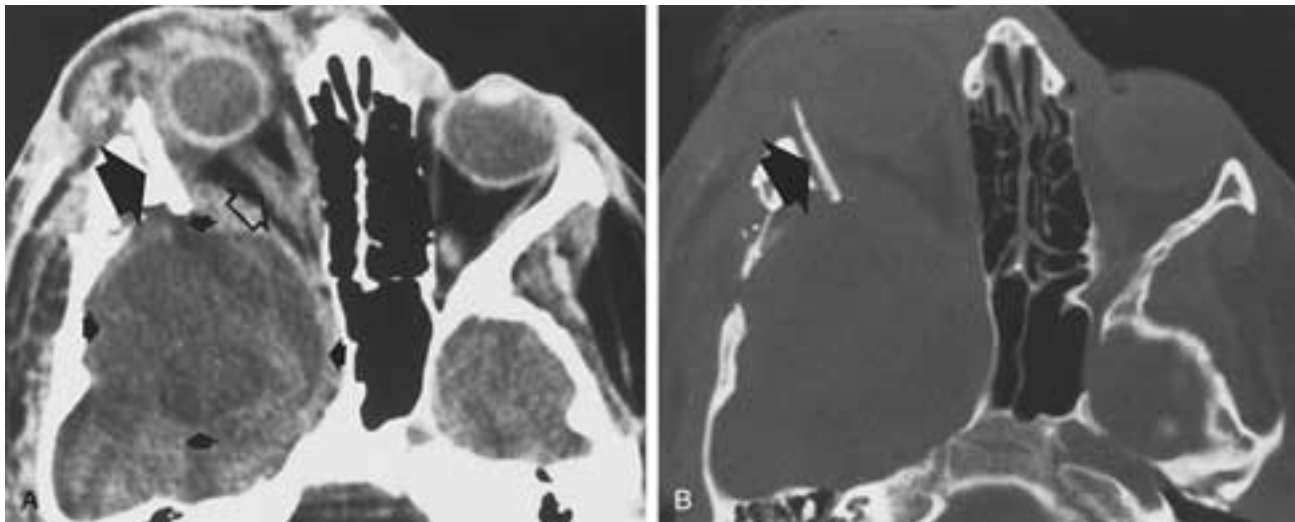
Neurofibromatosis. The patient had previous surgery for correction of an orbital deformity. A, Axial CT scan. Note the bone graft along the lateral margin of the right orbit (*large black arrow*). Note the normal left and dysplastic right greater wing of the sphenoid bone, with anterior herniation of the porencephalic cyst of the temporal lobe (*small arrows*) covered by dura. The right optic nerve is enlarged (*open arrow*), and the right globe is proptotic. Enlargement of the optic nerve is thought to be caused by optic nerve glioma. B, Osseous abnormalities are better seen on this bone detail image. (From Linder B et al. CT and MRI of orbital abnormalities in neurofibromatosis and selected craniofacial anomalies. *Radiol Clin North Am* 1987;25:787.)
